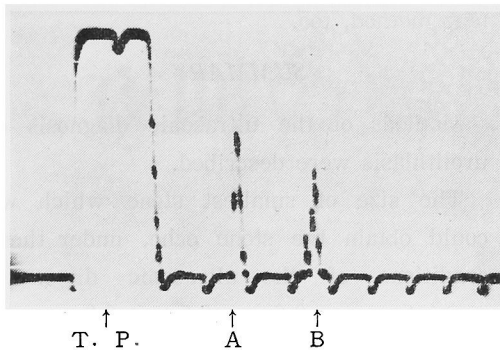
Ultrasono-echogram of Exposed Kidney with Stone.
